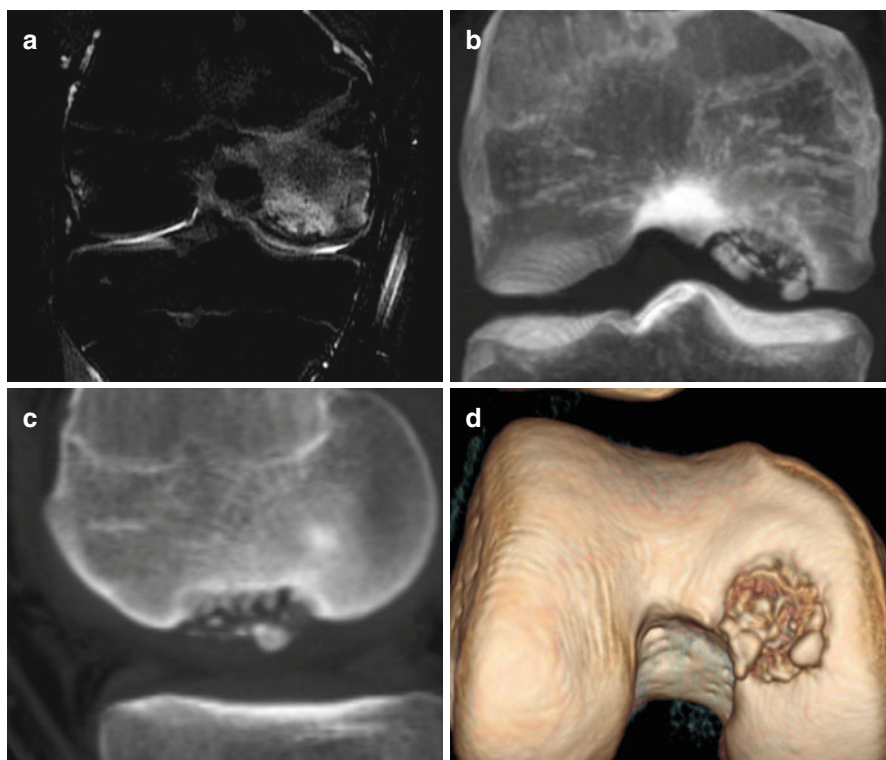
An 8-year-old male patient affected by Koenig disease. (a) STIR sequence on the coronal plane shows a subchondral area of marrow edema involving both the articular cartilage and the lateral aspect of the internal femoral condyle, typical signs of osteochondritis. (b–d) Coronal, sagittal, and VRT CT reconstructions demonstrate irregularity and fragmentation of the articular cartilage of the internal femoral condyle
